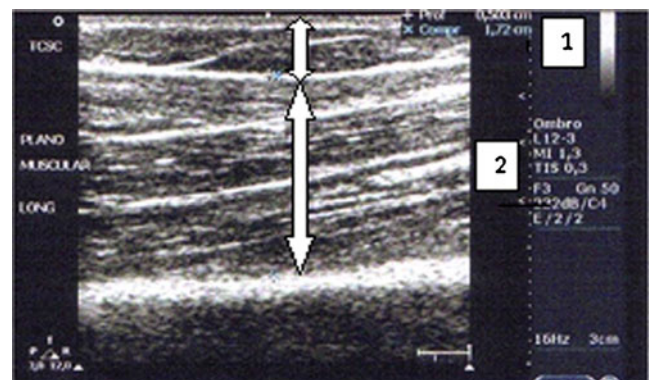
Ultrasound evaluation of the right upper limb in the longitudinal plane. Arrows: 1 thickness of the subcutaneous adipose tissue and 2 thickness of the muscle
